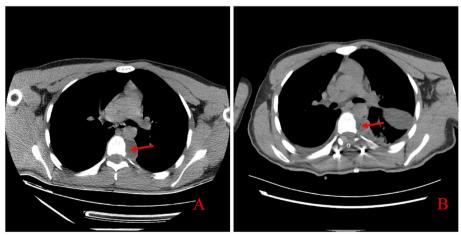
A Preoperative CT; The image shows paravertebral cystic soft tissue nodules, but it is impossible to accurately determine whether they communicate with the spinal canal (red arrow). B Postoperative CT; The image shows postoperative changes in the vertebral body and excision of cystic soft tissue (red arrow)
